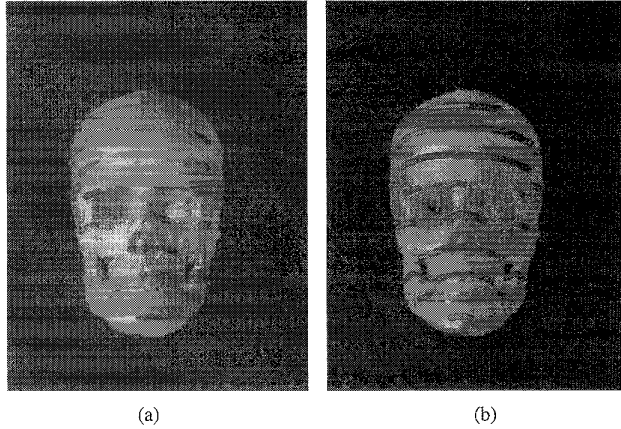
(a) Example of laser data (shown as large dots) overlaid on CT model of a plastic skull, after an initial alignment of the two point sets. Note the transparent laser points which are actually lying inside the skull. (b) Example of registered laser data (shown as large dots) overlaid on CT model.
